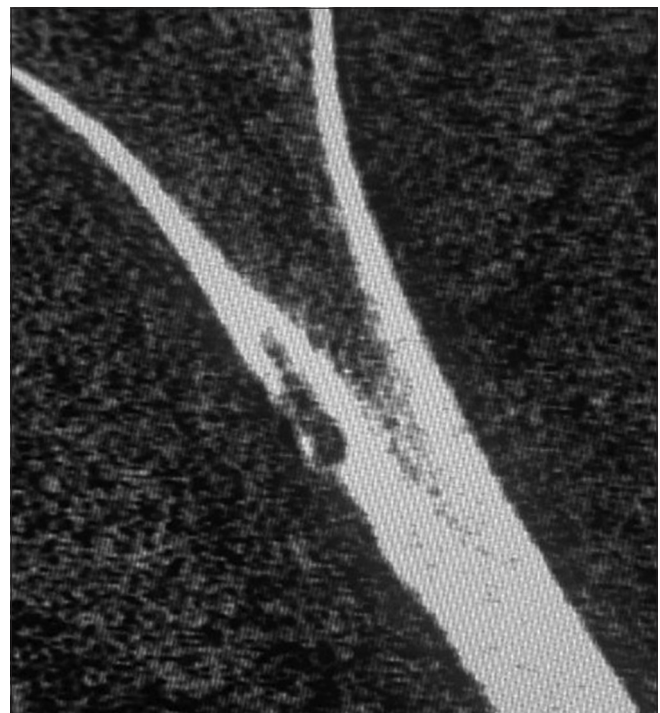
Humerus coronal CT showing well-defined cortical thickening, expansion, mild irregularity on the endosteal surface with irregular intracortical lucency at the deltoid muscle attachment area on the lateral side of the right humerus
